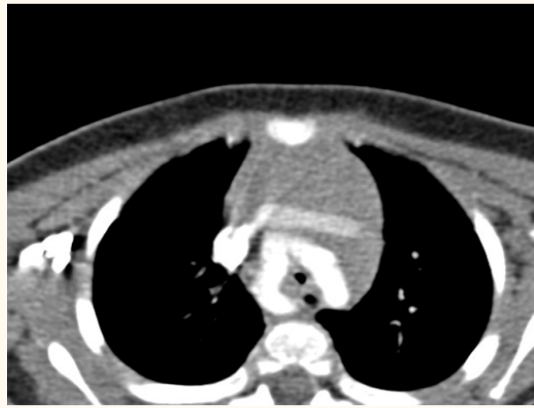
Axial computed tomography angiography image of the first case, demonstrating both aortic arches with a mildly compressed trachea and oesophagus.
